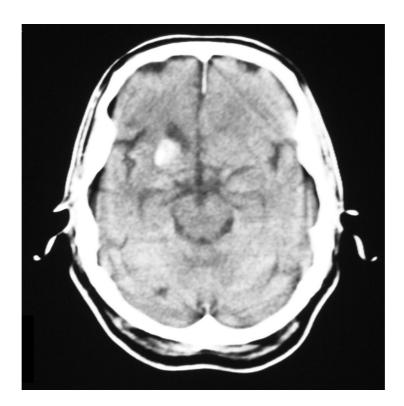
CT scan of the Brain on the 8th February 2006 showing the recurrence of the right basal ganglia bleed while not on antiplatelets
